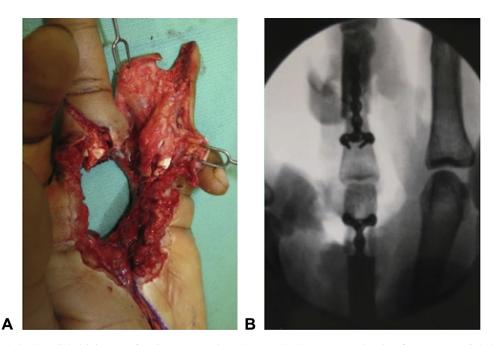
Vascularized pedicled joint transfer. A Intraoperative photograph demonstrates the ring finger PIP pedicled transfer to the long finger MCP joint. B Intraoperative x-ray under fluoroscopy verifies appropriate fixation of the transferred PIP joint from the ring finger to the MCP joint of the middle finger.
